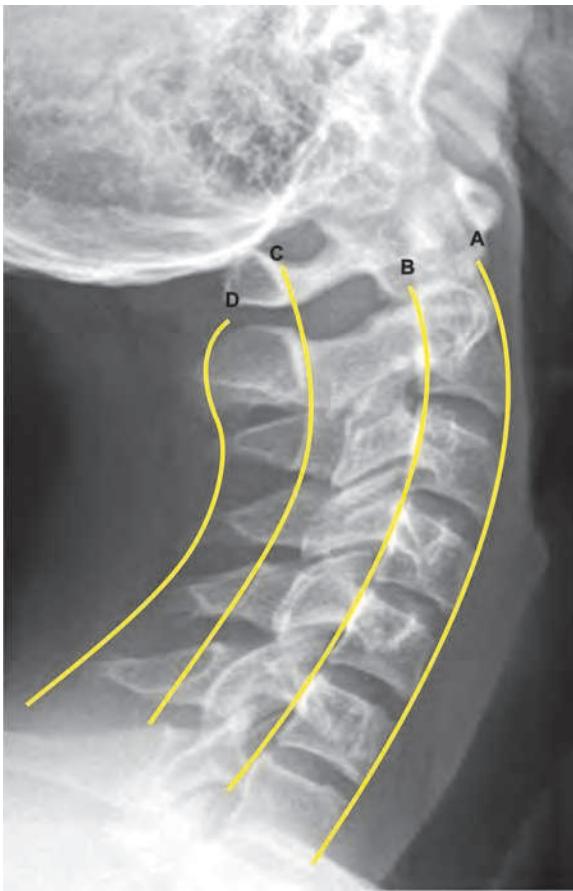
Normal cervical spine plain radiographs: Lateral view with the lines of alignment: Line A: anterior vertebral line; Line B: anterior spinal line; Line C: posterior spinal line; and Line D: spinous processes. Any discontinuity in any of the lines of alignment indicates spine injury
